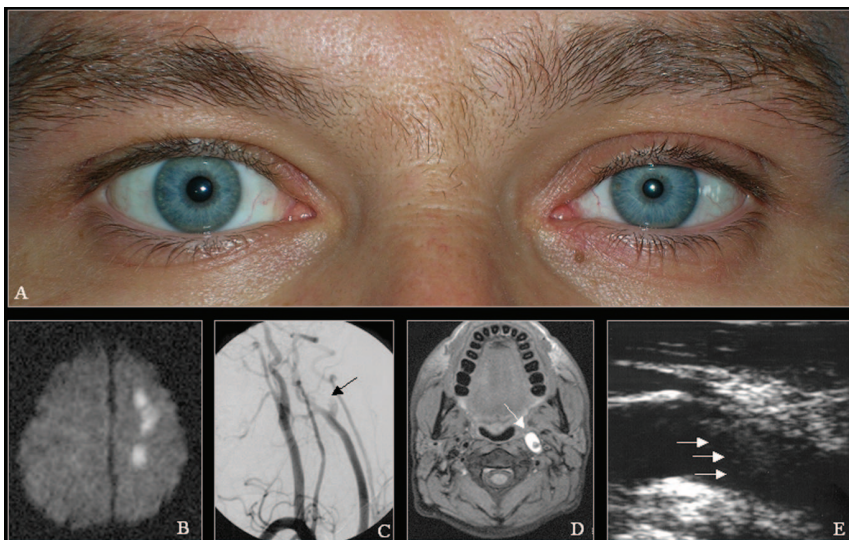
(A) Horner syndrome (miosis and ptosis). (B) Multiple left frontoparietal acute ischemic lesions on DW MRI. (C) Carotid angiography with evidence of left extracranial ICA occlusion. (D) ICA mural hematoma due to dissection evident on MRI scan. (E) Intimal flap (arrows) appearance on Duplex scan, pathognomonic sign of dissection.
